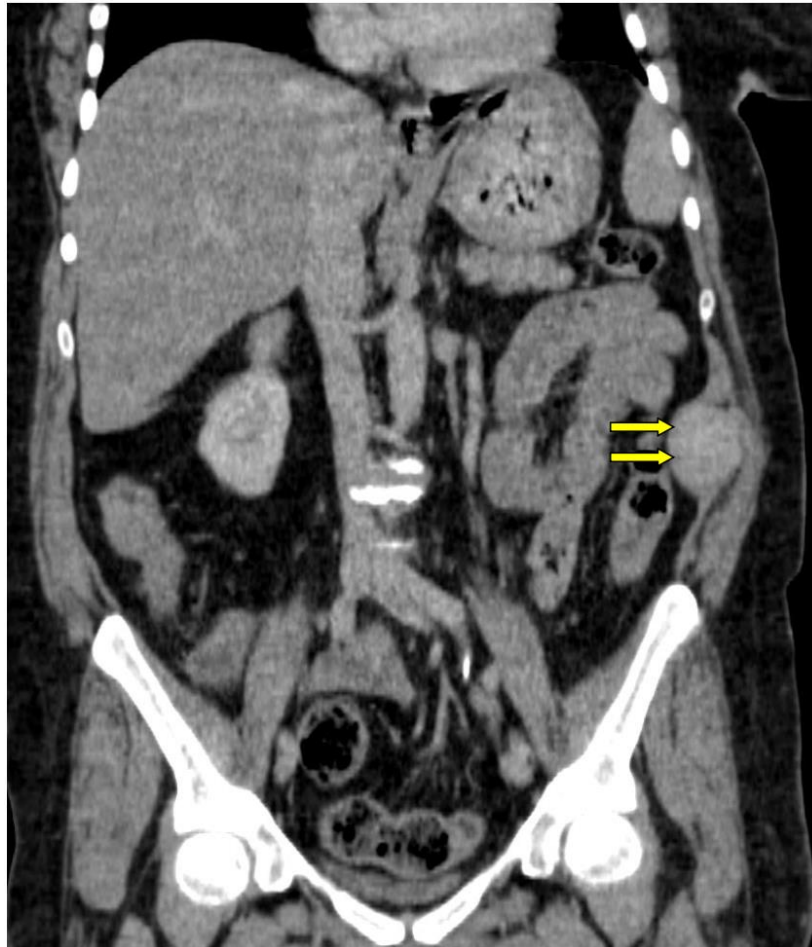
(a, b): Abdominal CT scan with PDC injection; portal phase (a: axial section, b: coronal section) portal phase homogenization (arrow)
